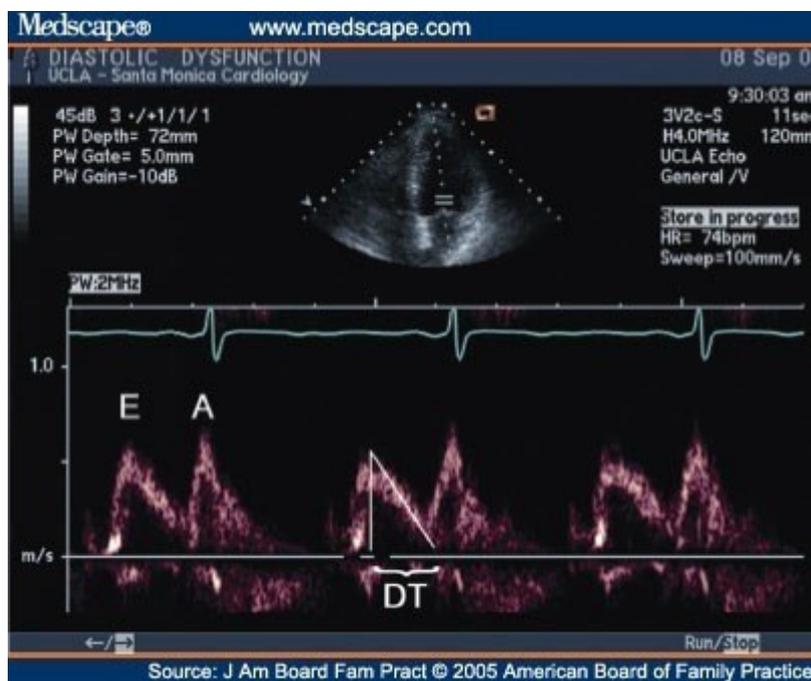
Echocardiography Demonstrating Diastolic Dysfunction
